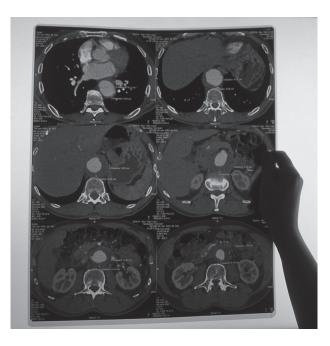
Old CT scanners could produce only images of thick (1 cm) axial sections of the body.
